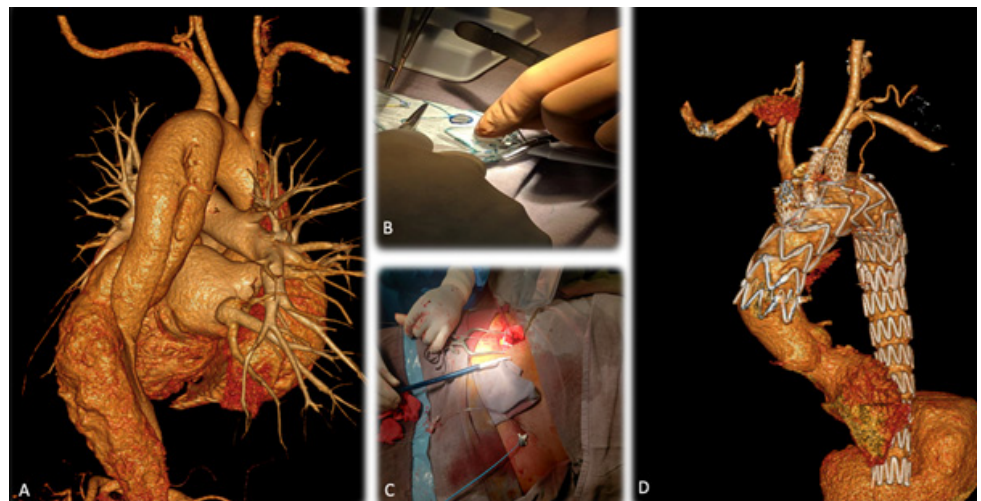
CT angiogram showing type B dissecting aneurysm (A) . The aortic graft was fenestrated (B) after the femoral cutdown (C). Follow up CT after 1 year (D) shows the aortic graft with all the 3 fenestrated grafts in the arch vessels with complete resolution of the dissecting aneurysm
